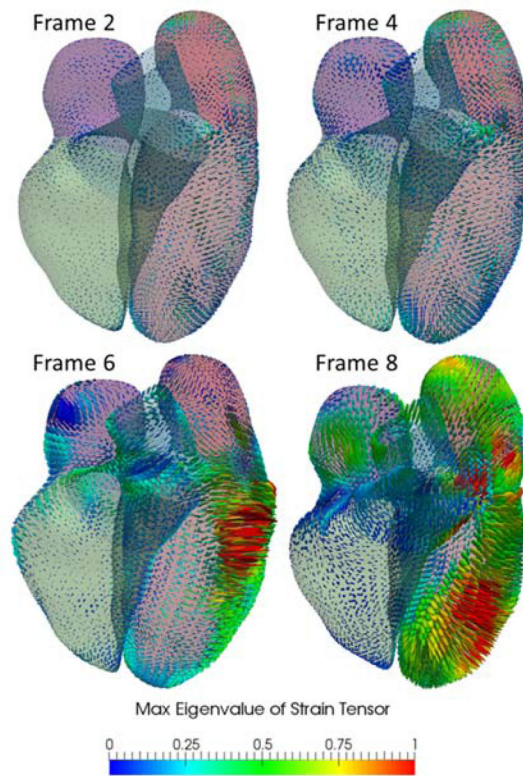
Visualization of heart motion and deformation on 3D myocardial surface. The Green-Lagrange strain tensor is calculated for all ten frames from 4D CT data, from which the geometry in the first frame is used as the reference configuration. The color-coded max eigenvalue of the strain tensor were shown in four sample frames from an animation sequence.
